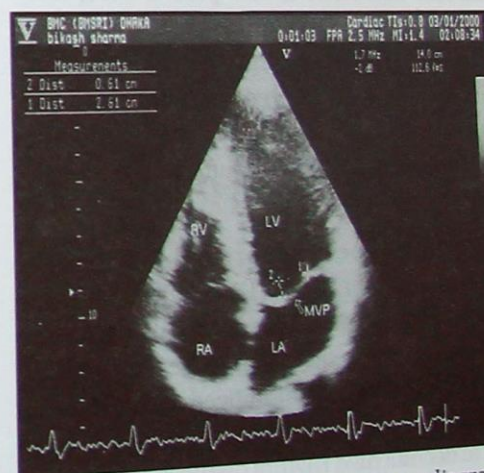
Apical four-chamber echocardiogram of a patient with mitral valve prolapse demonstrating a curved anterior mitral leaflet that extends 6 mm beyond the plane of the mitral annulus (dotted line).
